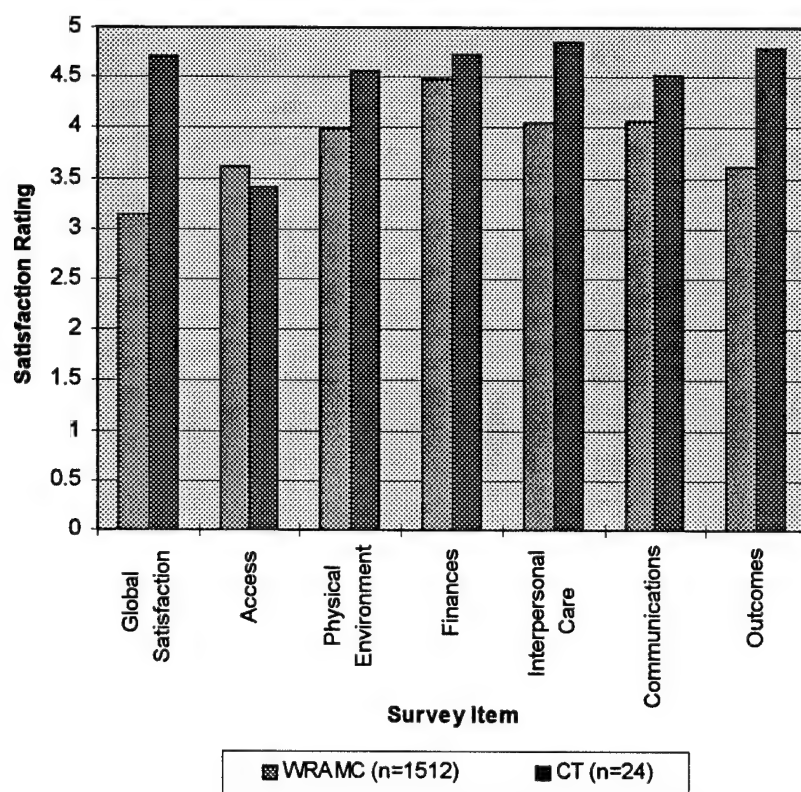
CT patient satisfaction as compared to WRAMC patient satisfaction. Satisfaction scale: 1 = poor, 2 = fair, 3 = good, 4 = very good, 5 = excellent.
